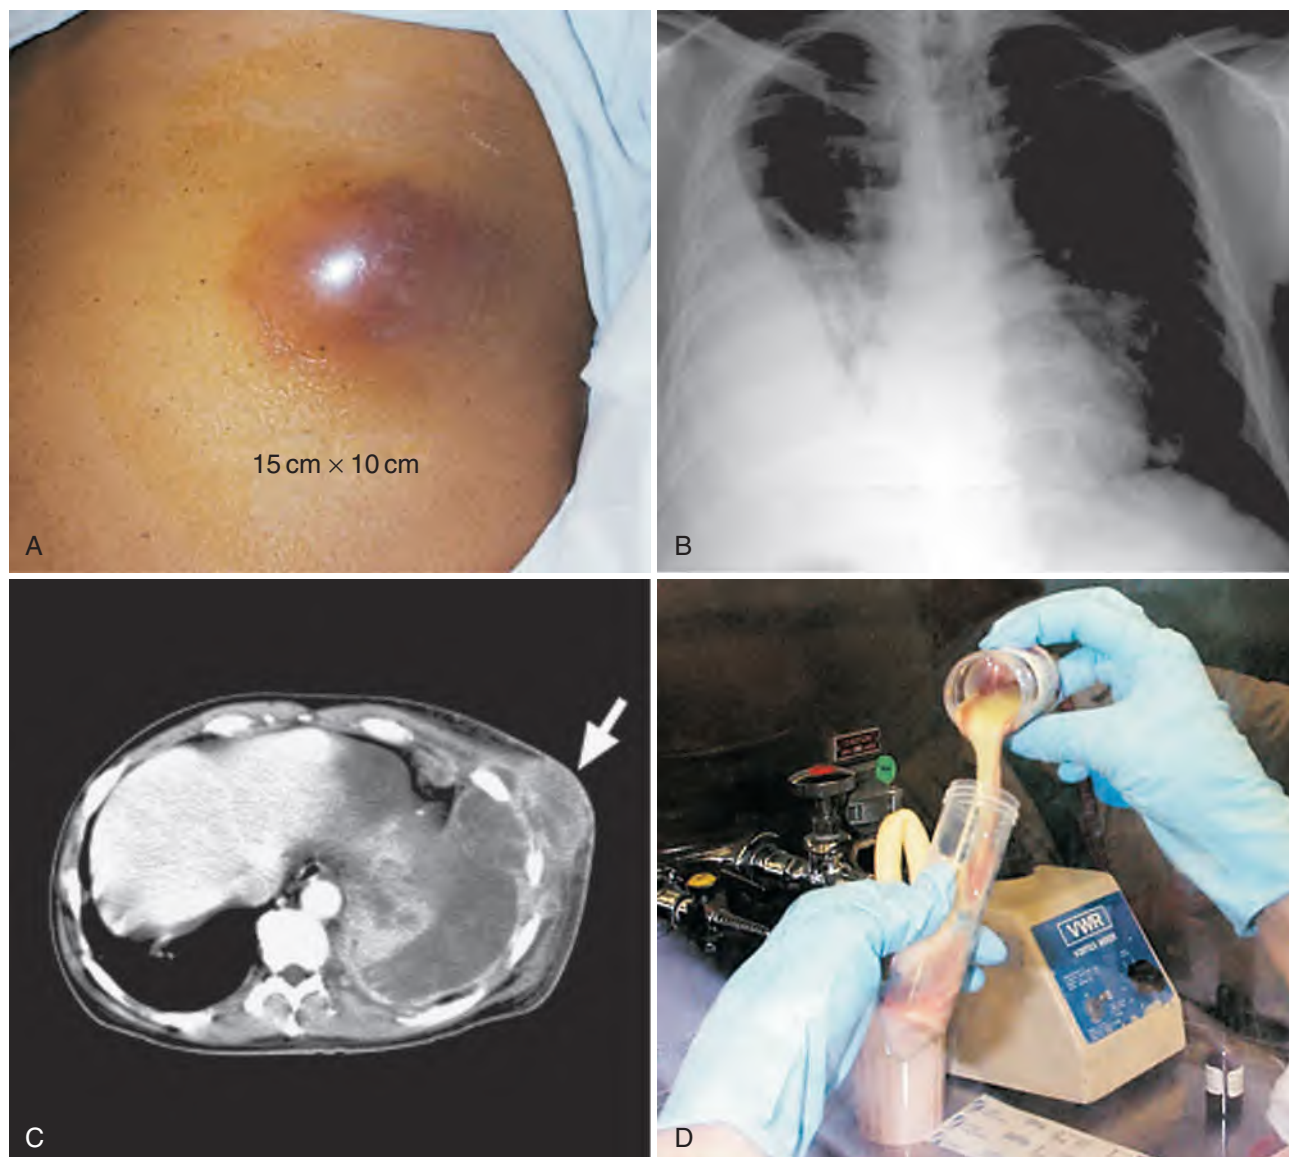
Thoracic actinomycosis. (A) Chest wall mass. (B and C) Chest radiograph and computed tomography demonstrating the pulmonary infiltrate, pleural effusion, and pleural and chest wall extension (arrow). (D) Purulent pleural fluid obtained by means of aspiration. (Courtesy Dr. C.-B. Hsiao.)
